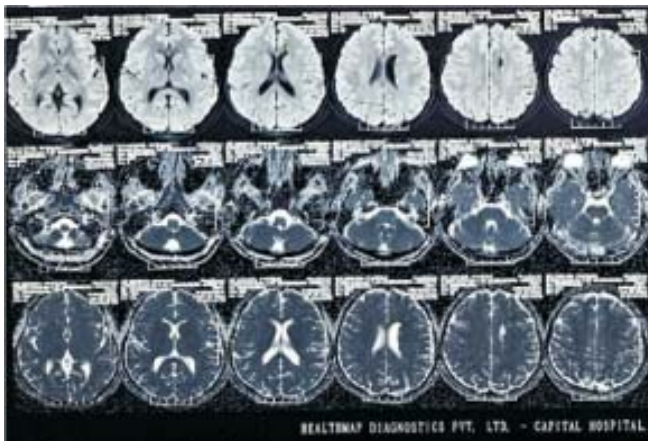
MRI-Brain showed multiple small nodular subependymal lesions in left lateral ventricle suggestive of grey matter heterotopia.
